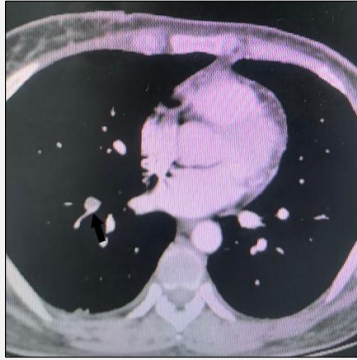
Chest enhancement CT suggesting embolism of the right lower pulmonary artery branch.
